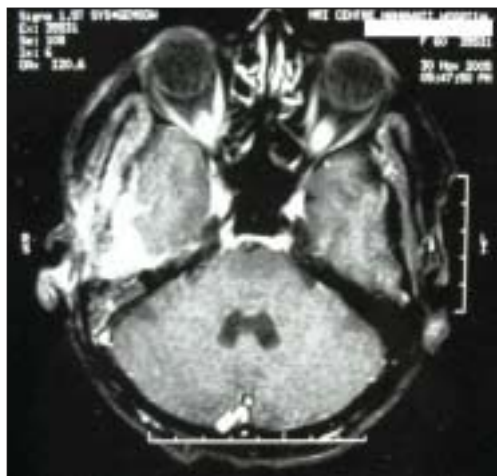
MRI scan showing a mass lesion in the right temporal lobe region extending into the auditory canal
